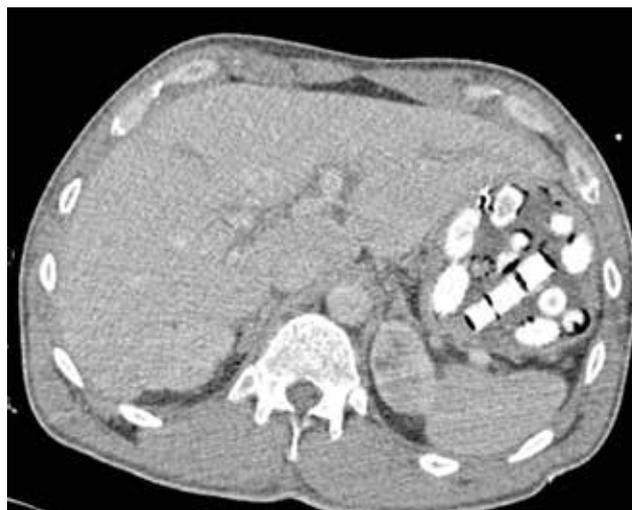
Abdominal CT scan: packages in stomach
